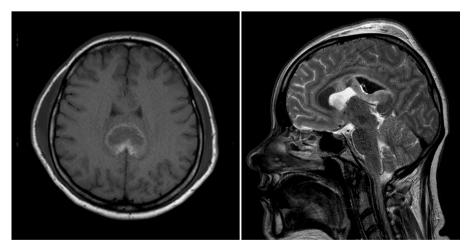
MRI of the brain done one month after the impact.
